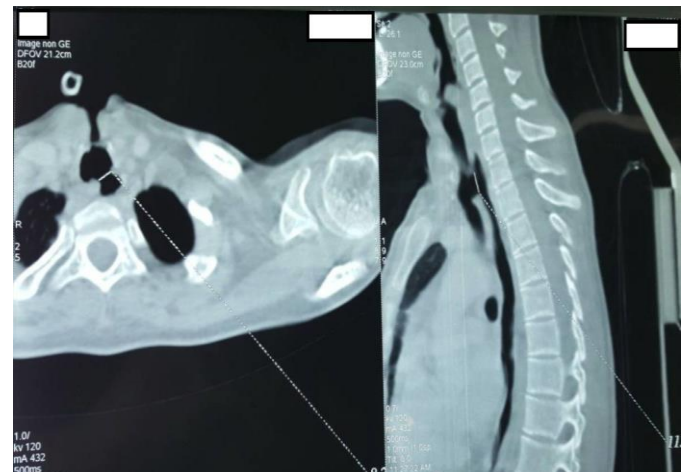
CT images showing the size and location of the esophageal-tracheal fistula.
